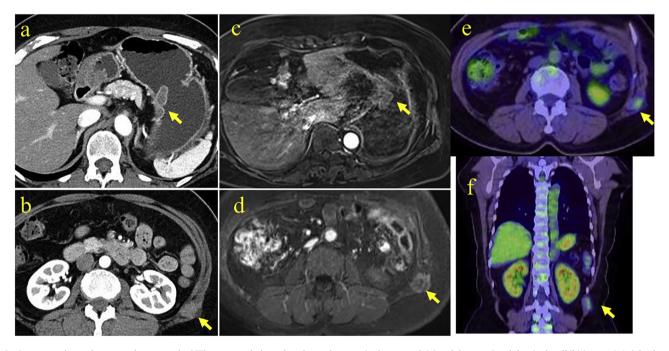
Contrast-enhanced computed tomography (CT) scan revealed poorly enhanced tumors in the stomach (a) and the anterior abdominal wall (b) (arrows). Axial enhanced T1-weighted image on magnetic resonance imaging showed similarly homogeneous moderate enhancement in both gastric (c) and abdominal wall lesions (d) (arrows). 18F-fluorodeoxyglucose positron emission tomography CT scan revealed 18FDG uptake only in the abdominal wall lesion with a maximum standardized uptake value of 1.92 (e, f) (arrows).
